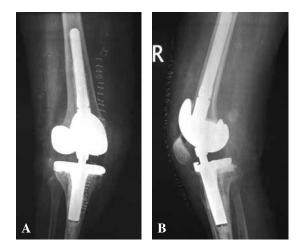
Knee dislocation following primary total knee replacement after RHKTM prosthesis. Post operative AP radiograph. A : AP view ; B : Lateral view.
